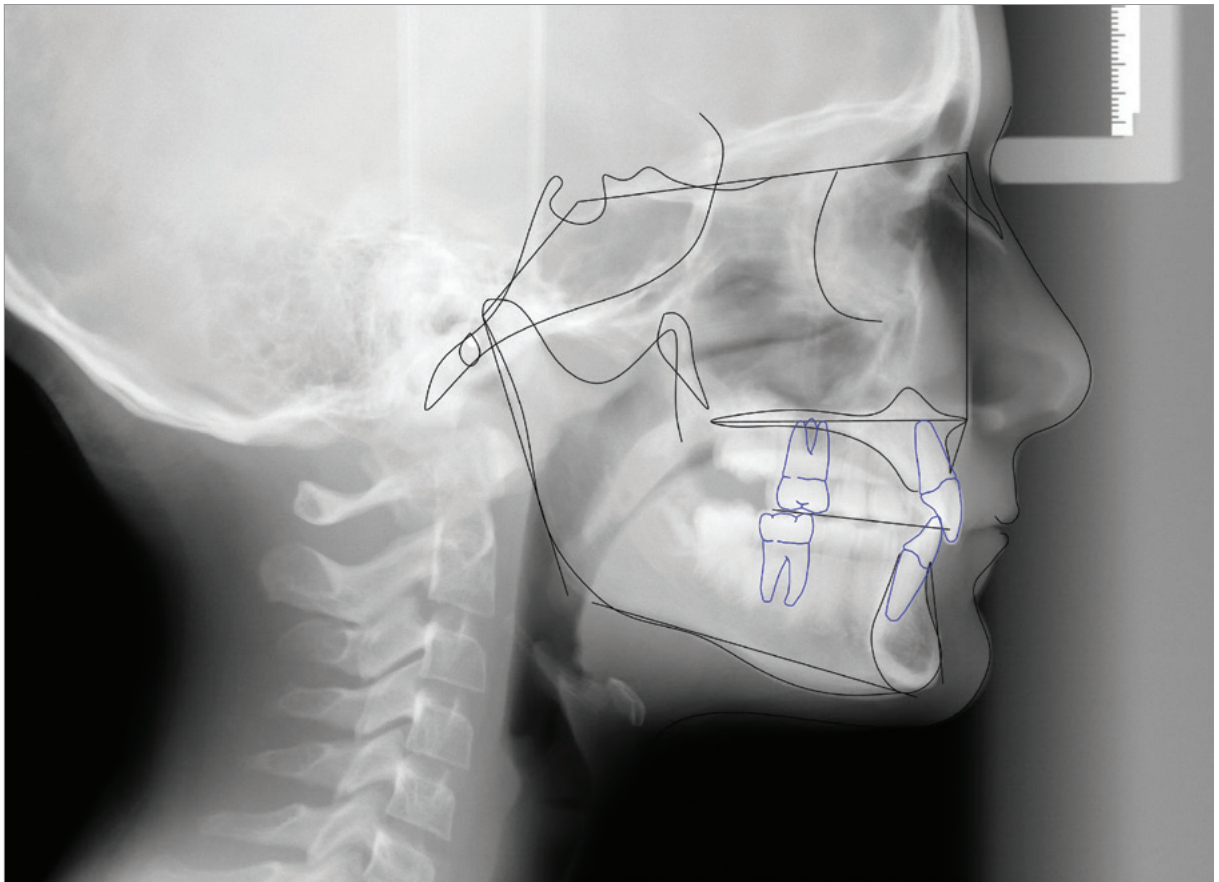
Pretreatment cephalometric radiograph and tracing.
